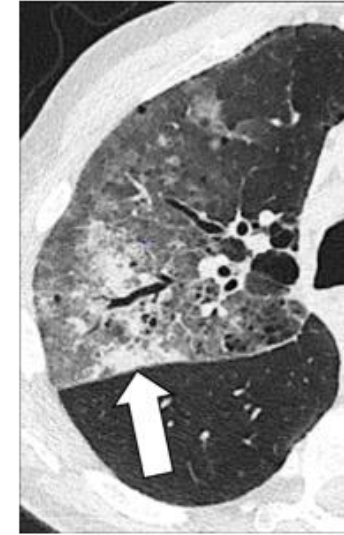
Ground-glass opacities and consolidation: Transverse CT image of the right lung shows ground-glass opacities and focal consolidation (arrow). [click to return to page 6, page 9](#)
